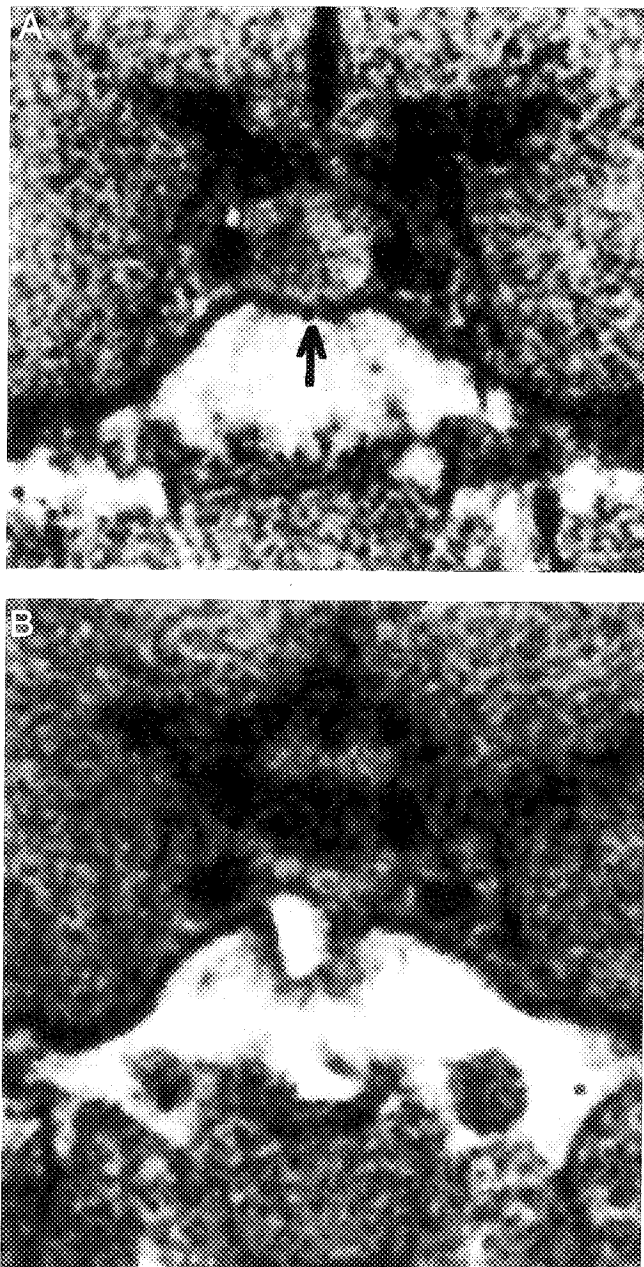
Cranial MRI of a 6.5-yr-old patient with gigantism showing a 1.8×1.8 -cm cystic adenoma of the pituitary gland. A, preoperative MRI; B, MRI 2 months after enucleation of the adenoma.
